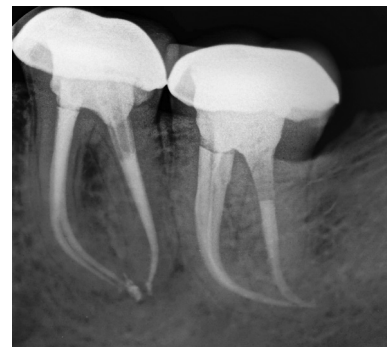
Periapical radiograph demonstrating the fit of the plastic inserts of Protaper obturators to the corrected working length (mandibular second molar) after canal negotiation with C+ and K-files and preparation with Protaper Next
